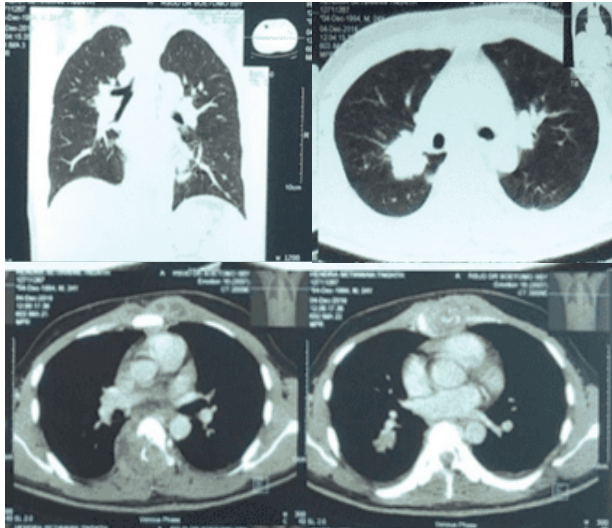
Right lung central mass findings that show contrast enhancement on CT scan thorax result
